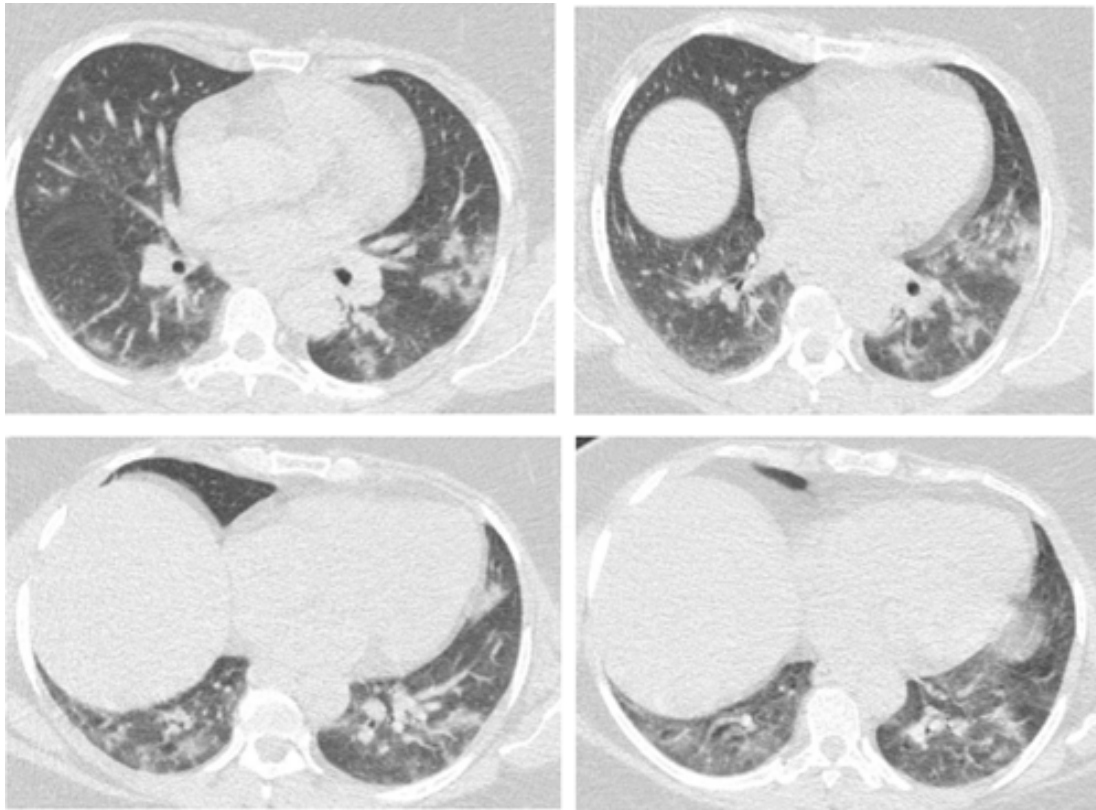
Computed tomography of thorax evidencing ground-glass opacities and sparse bilateral foci of consolidation, predominantly in the peripheral with pulmonary involvement around 25-50%.
